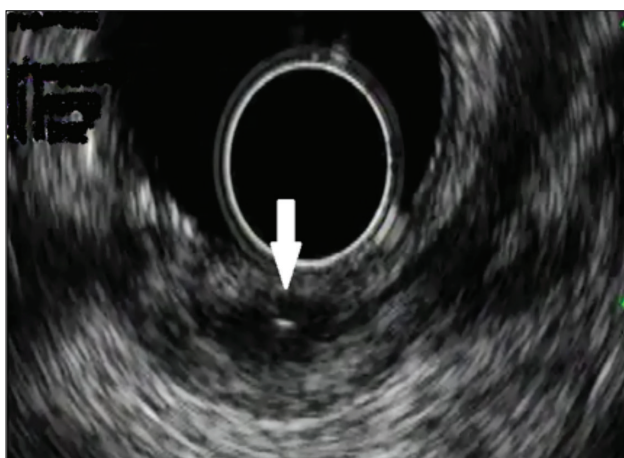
Endoscopic ultrasound images of the rectal lesion showing a predominantly hypoechoic lesion with a linear hyperechoic image in its interior (white arrow).
